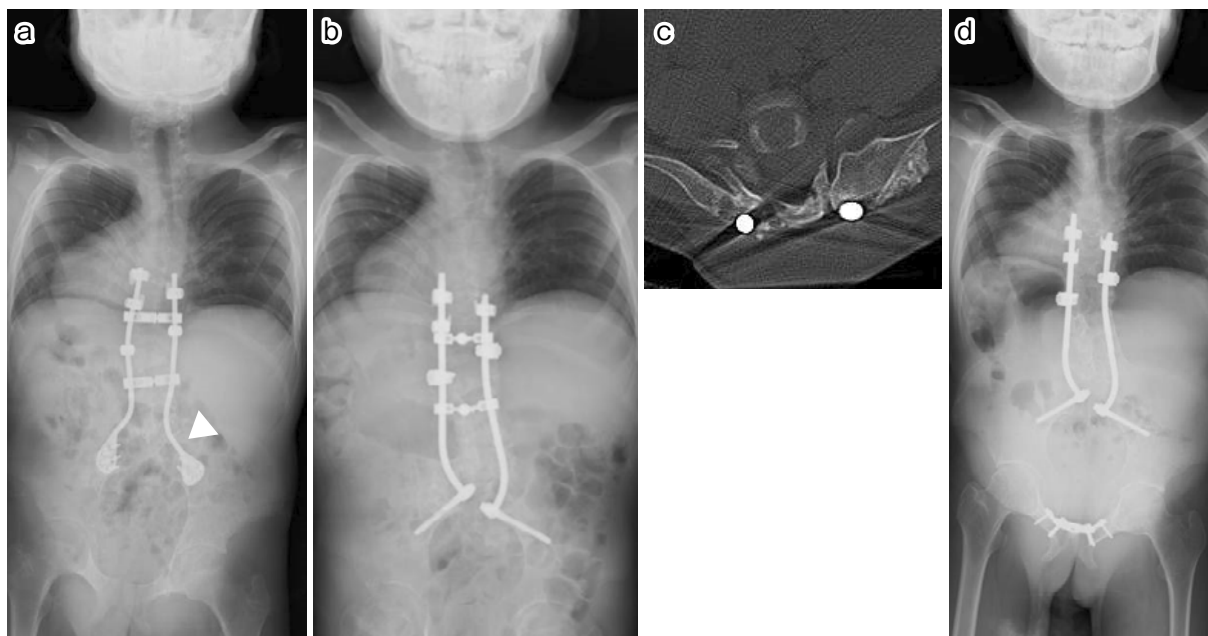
a: 1-year postoperative X-ray image showing a right rod breakage (white arrowhead); b: X-ray showing posterior fixation with pedicle and iliac screws after removing U.H.U spinal implant; c: CT shows delayed union at the spinopelvic junction after two bone graft augmentations. d: X-ray shows rigid fixation at the pubic symphysis.
